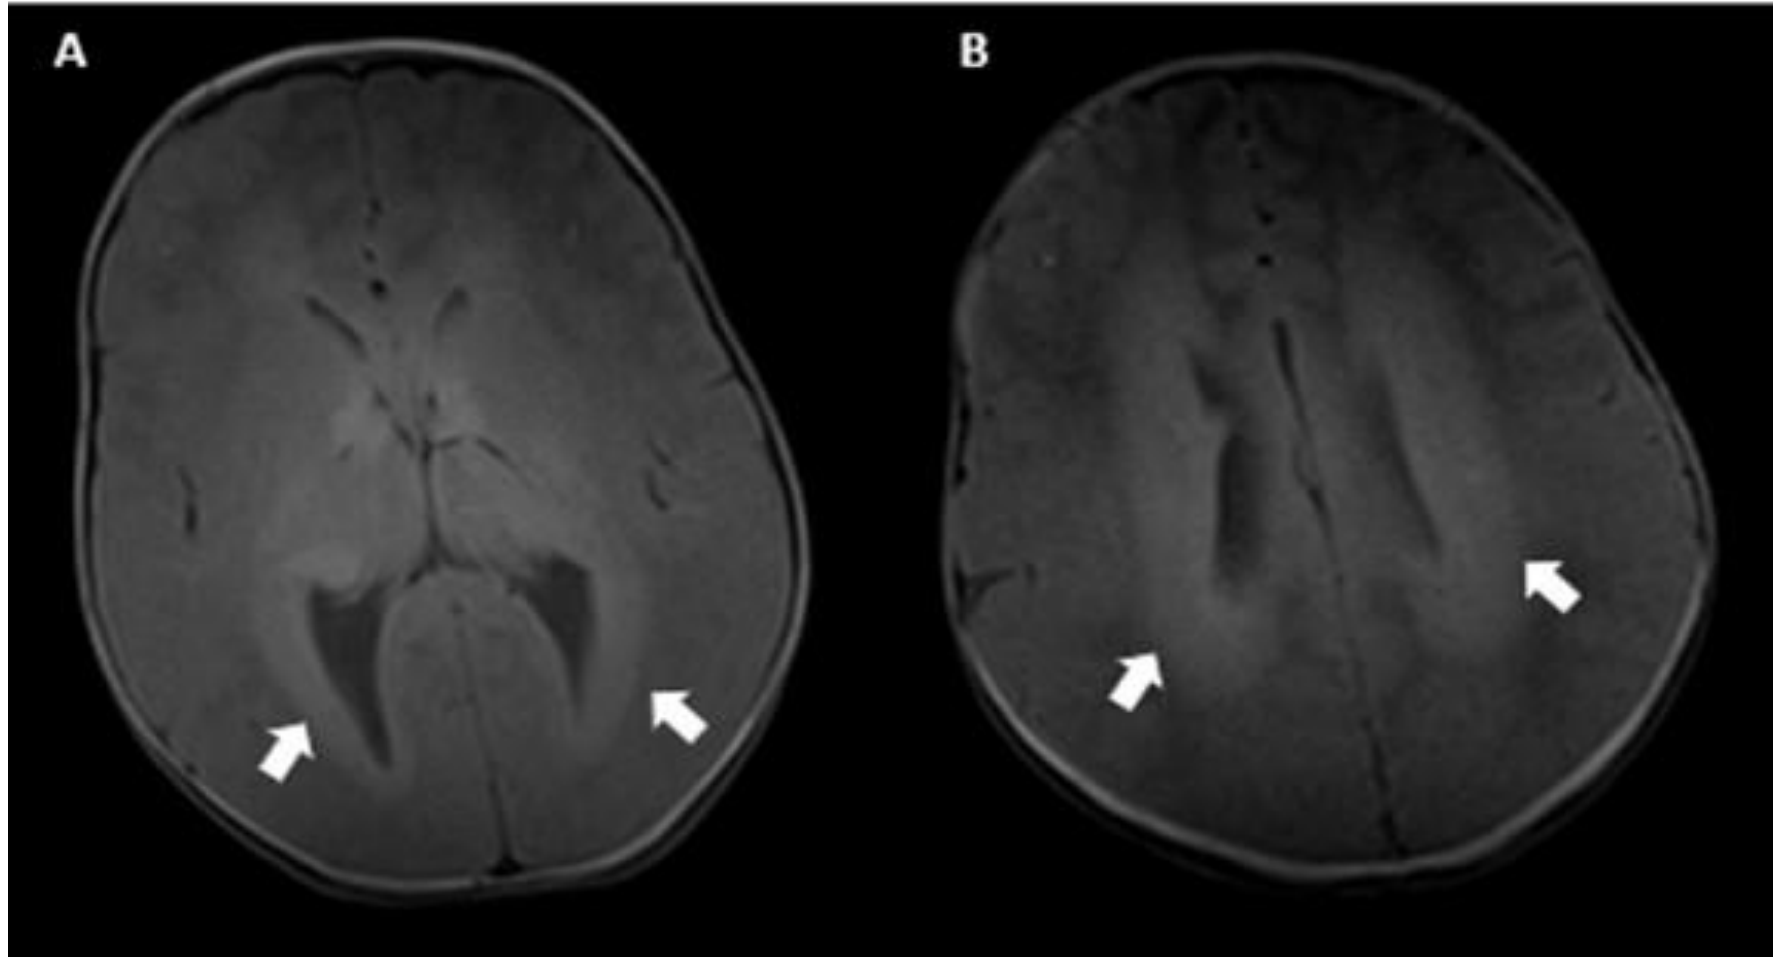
A, B) Brain MRI showing a band of abnormal signal surrounding the lateral ventricles symmetrically, which follows gray matter on T1 axial images, and bilateral ventriculomegaly.
